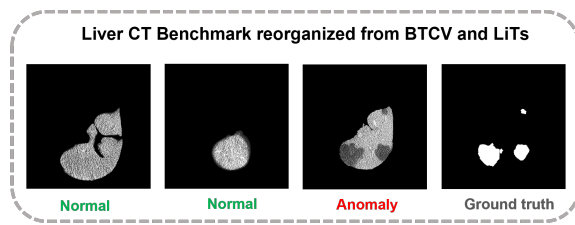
Visualization of our proposed Liver CT benchmark.
